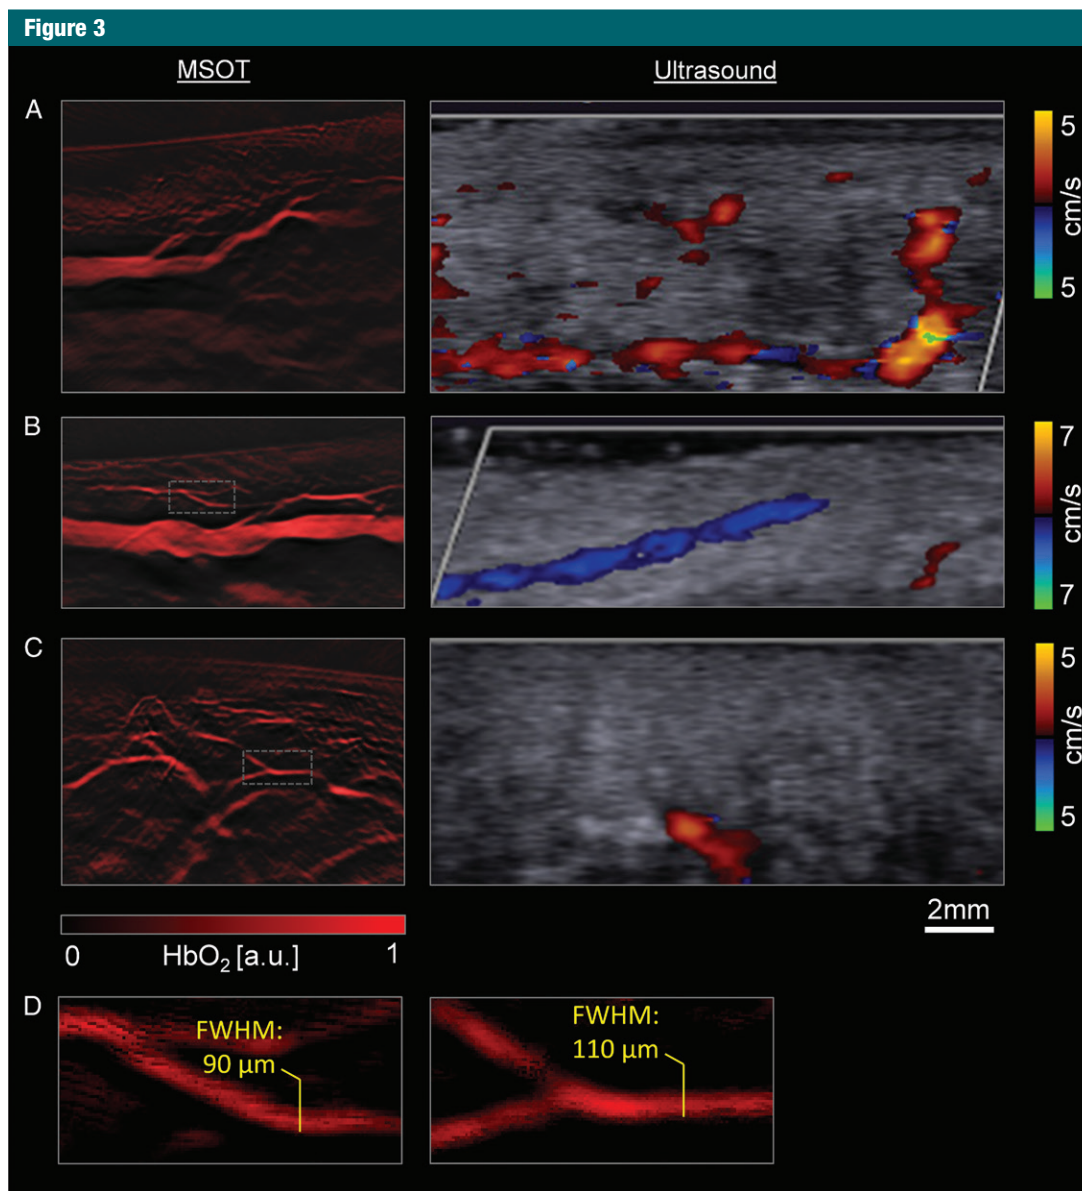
MSOT imaging of small blood vessels. Left column shows MSOT images, where oxyhemoglobin signal is superimposed in red on images acquired at 830 nm. Right column shows duplex US images. All images are cropped to a region of interest. The skin is at the top of each panel so that MSOT and US images are approximately aligned. *A, B*, Medial side of the hallux in two different subjects. *C*, Distal tip of the hallux. MSOT hemoglobin contrast provides more sensitive detection of small blood vessels than does clinical Doppler US. *D*, Zoomed-in MSOT images of the regions indicated by boxes in *B*, and *C*, show features belonging to the smallest structures clearly identified as blood vessels. The diameters at the yellow lines are provided as the full width at half maximum (*FWHM*). *a.u.* = arbitrary unit.
